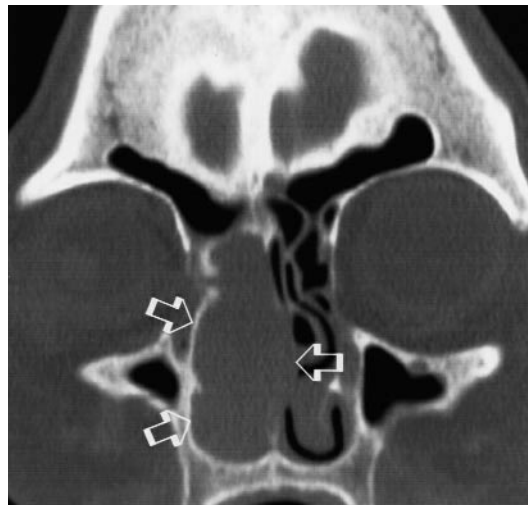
Coronal computed tomography (CT) scan of the same patient as in Figure 2. Notice the lateral and medial extent of the lymphoma (hollow arrows), traversing the septum and extending superiorly to the frontal recess.
